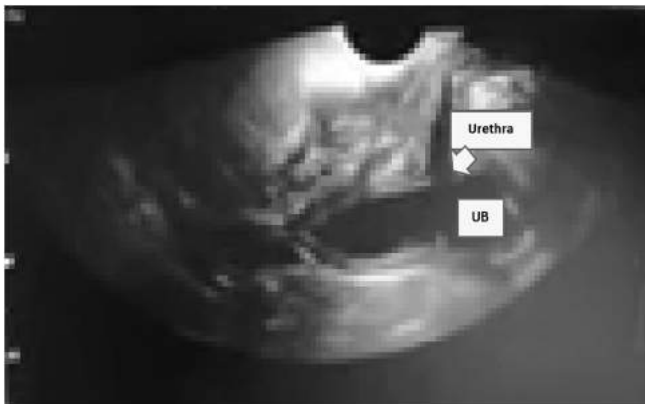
Transrectal sonogram showing the urinary bladder and urethra.
